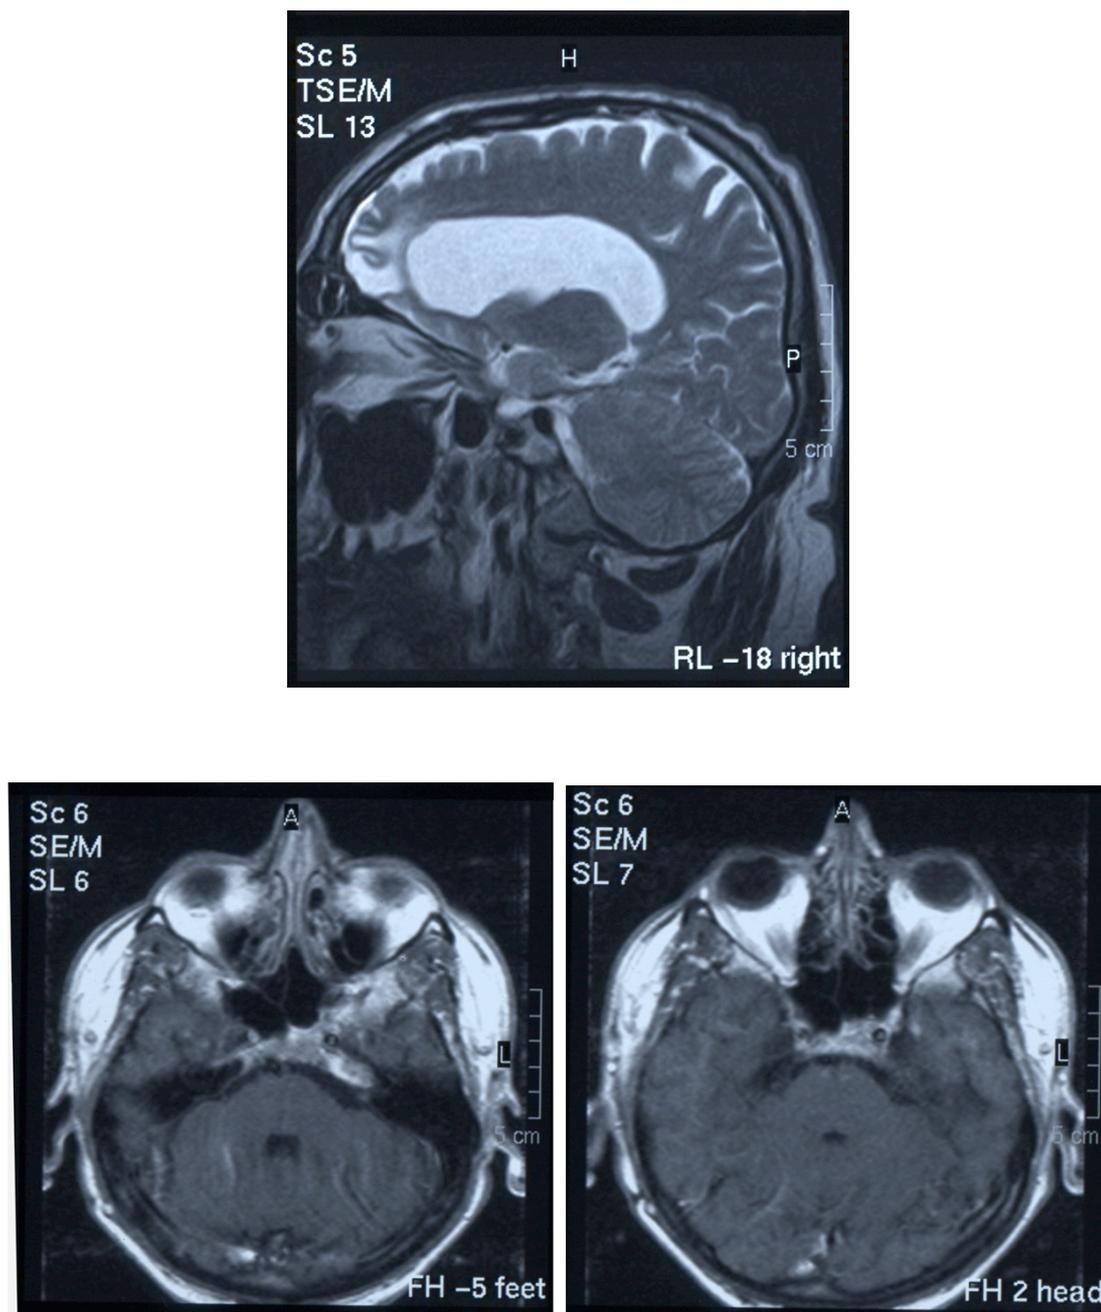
MRI of patient LE. Surgery was conducted to remove a tumour located under the left optic nerve, when he was at the age of 46. The removed tumour obliterated the optic nerve and suppressed the optic chiasm.
